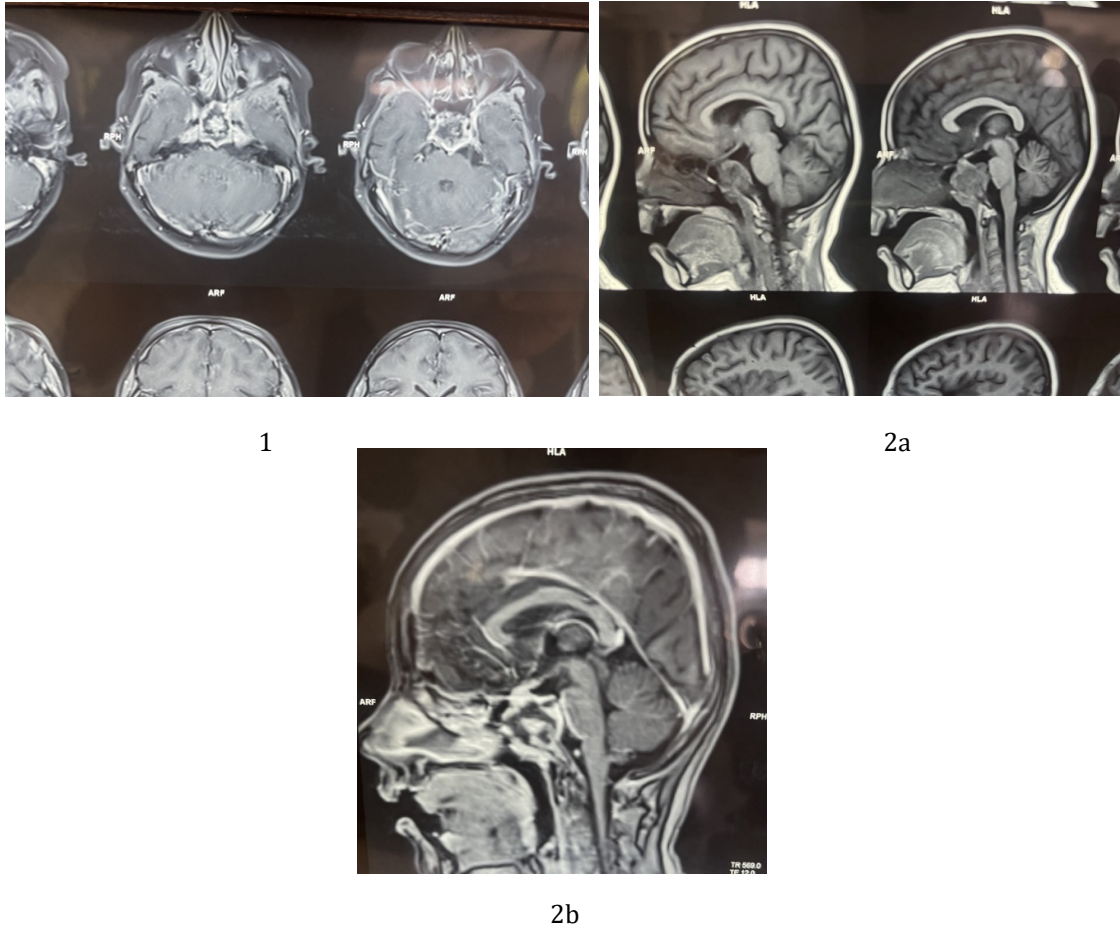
MRI brain with contrast showing the clival lesion.
